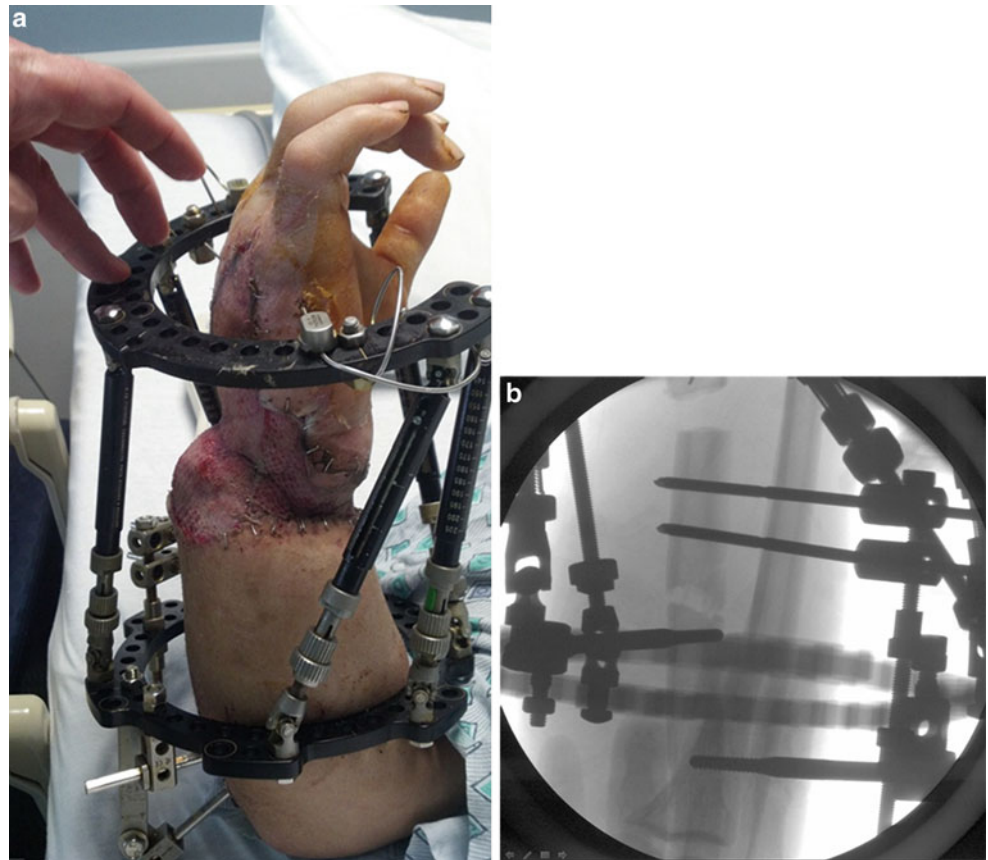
(a) Clinical photograph after distraction of forearm. Note the threaded rod attached to the proximal ring and attached to the radius with two half pins. Two 4-point D/C counters drive the threaded rod and the radial lengthening. (b) Clinical photograph corresponding to (a) (See Fig. 4b for radiographic appearance of radial osteotomy)
